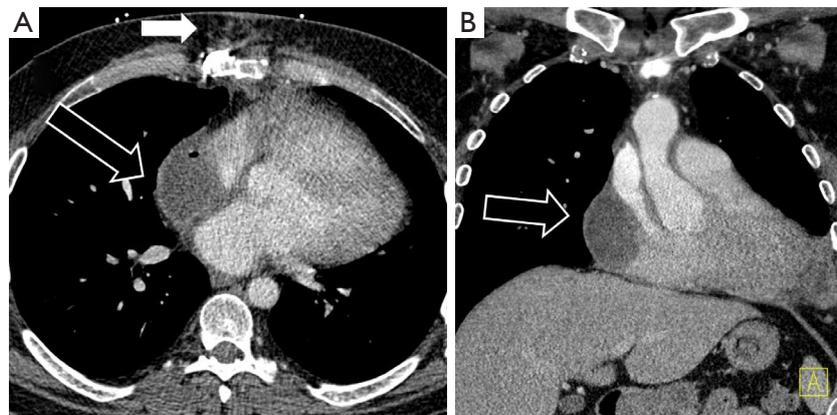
29-year-old male status post heart transplant with a pericardial abscess. Axial CT image after the administration of contrast demonstrated inflammatory changes in the sternum compatible with known infection (A, white arrow). A loculated pocket of fluid with small amount of gas is noted in the pericardium, immediately adjacent to the right atrium, compatible with intrapericardial abscess formation (A, black arrow; B, black arrow). CT, computed tomography.
